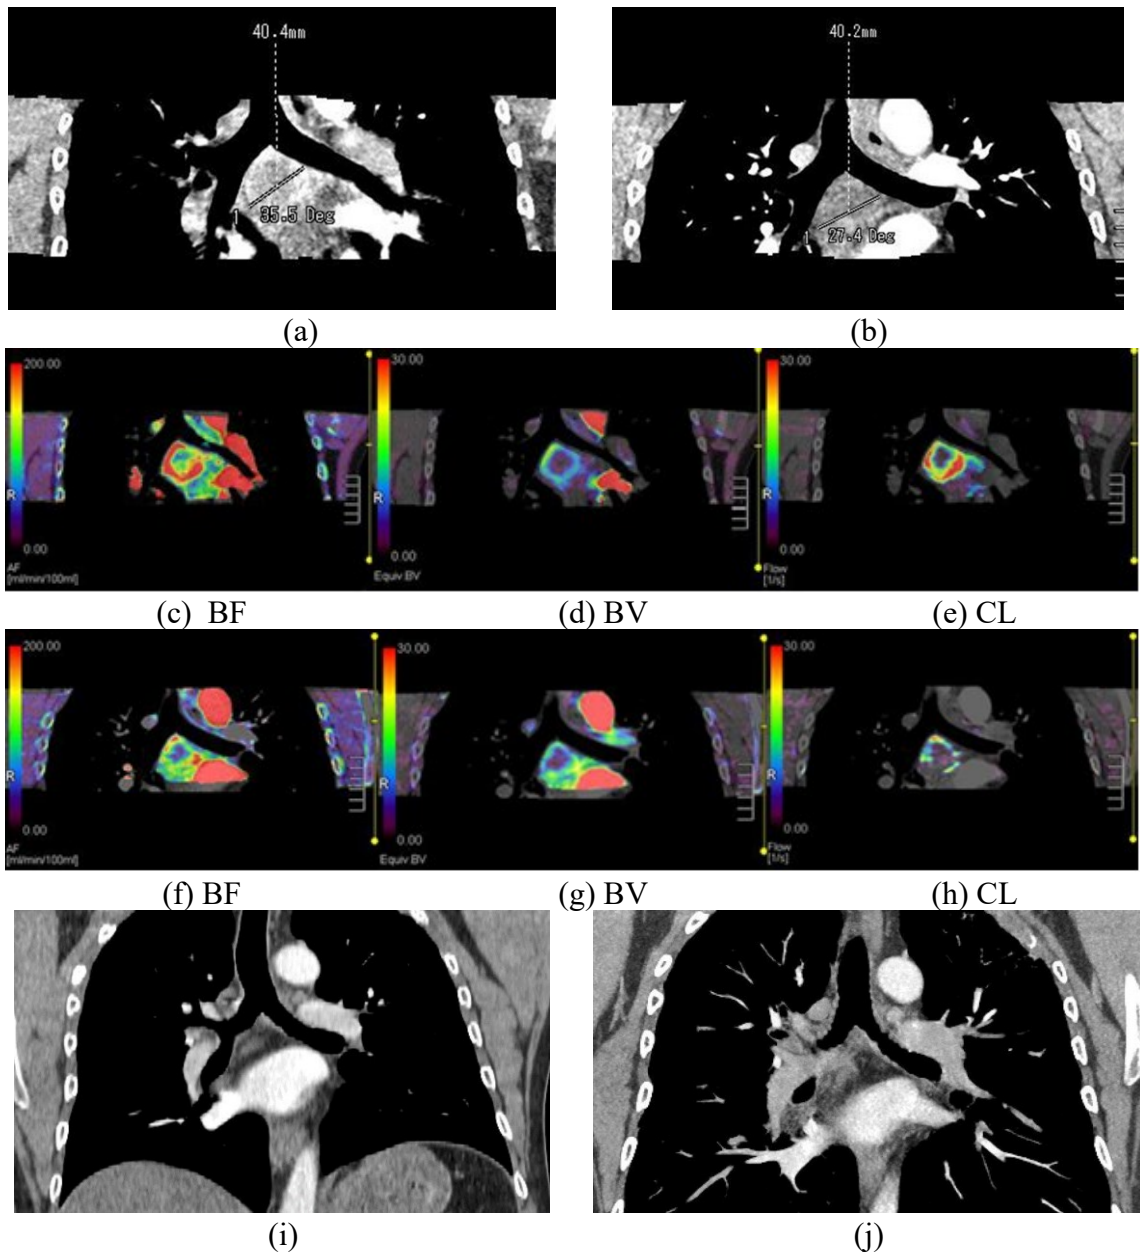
(a-j): (a, b) Subcarinal mediastinal lymph node metastasis of RCC before (a) and 1 month after therapy (b). No significant change in tumor size was observed after therapy, and the patient was categorized as SD according RECIST. (c, d, e) Parametric maps of BF, BV and CL before (c-e) and 1 month after therapy (f-h) show significant decrease of BF (c, f) and CL (d, g) after therapy, whereas no significant decrease of BV (e, h) was found. Follow-up CT 3 months (i) and 10 months (j) after therapy showed disappearance of the metastatic lesion and, therefore, confirmed response.
